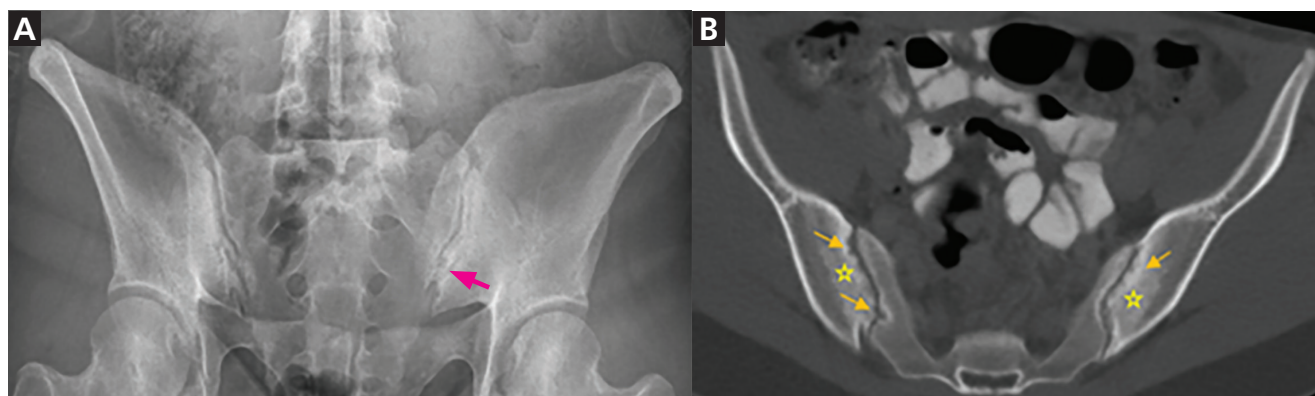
Imaging from a different patient showing radiographic features of ankylosing spondylitis. The (A) radiograph of the sacroiliac joints shows mild irregularity of the subchondral bone over the left inferior sacroiliac joint (pink arrow). The (B) axial computed tomography image of the sacroiliac joints shows bilateral erosions (yellow arrows) and sclerosis (yellow star) on the iliac side.
